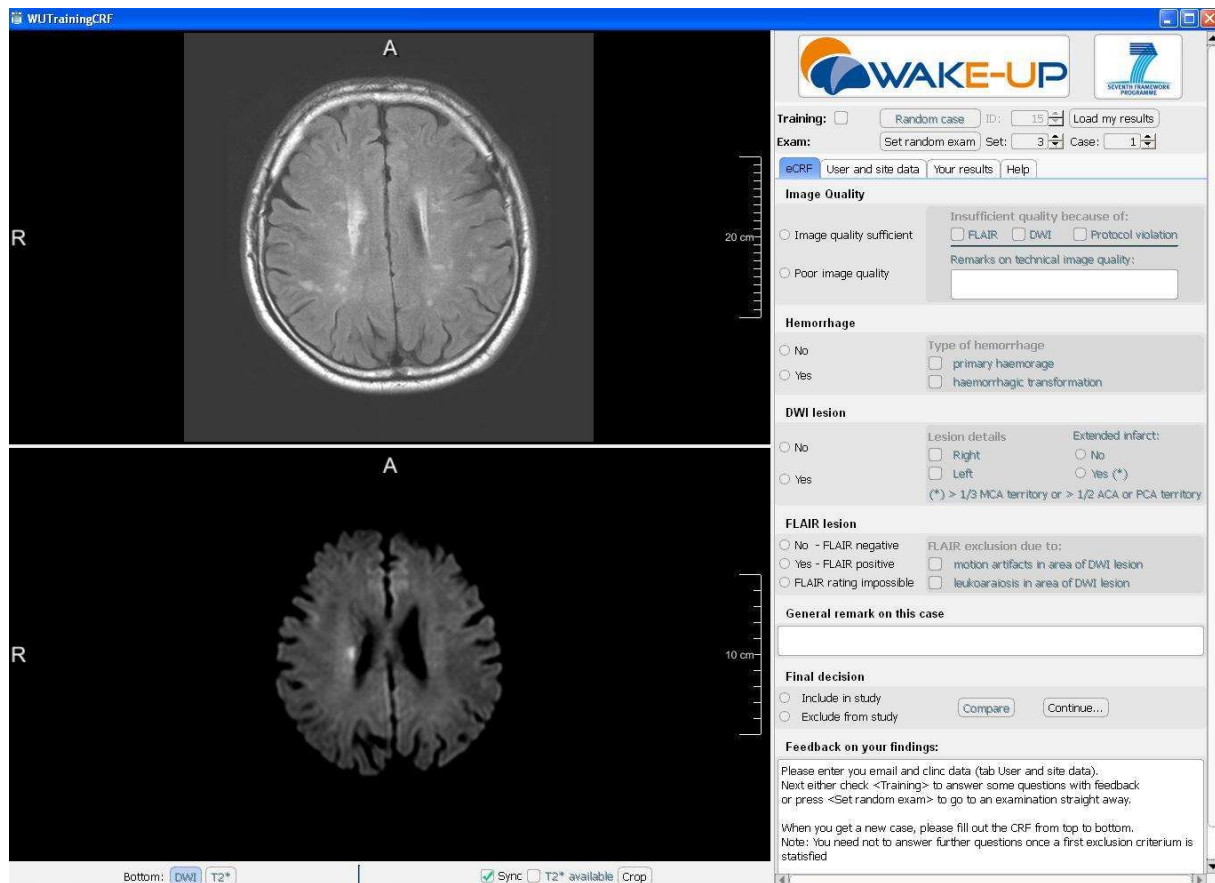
The graphic user interface of the WAKE UP investigator training software. The left side of the screen hosts the imaging panel with two windows for parallel and synchronized viewing of two different series (for example DWI and FLAIR, as shown here). The right side of the screen hosts the electronic case report form (eCRF) with questions pertaining to the different inclusion and exclusion criteria. The bottom of the eCRF offers feedback to the investigators regarding their answers and therefore serves a teaching function. When ready to put their knowledge to the test, investigators would switch from the training to the exam mode with a simple click in the checkbox at the top left corner of the eCRF.
